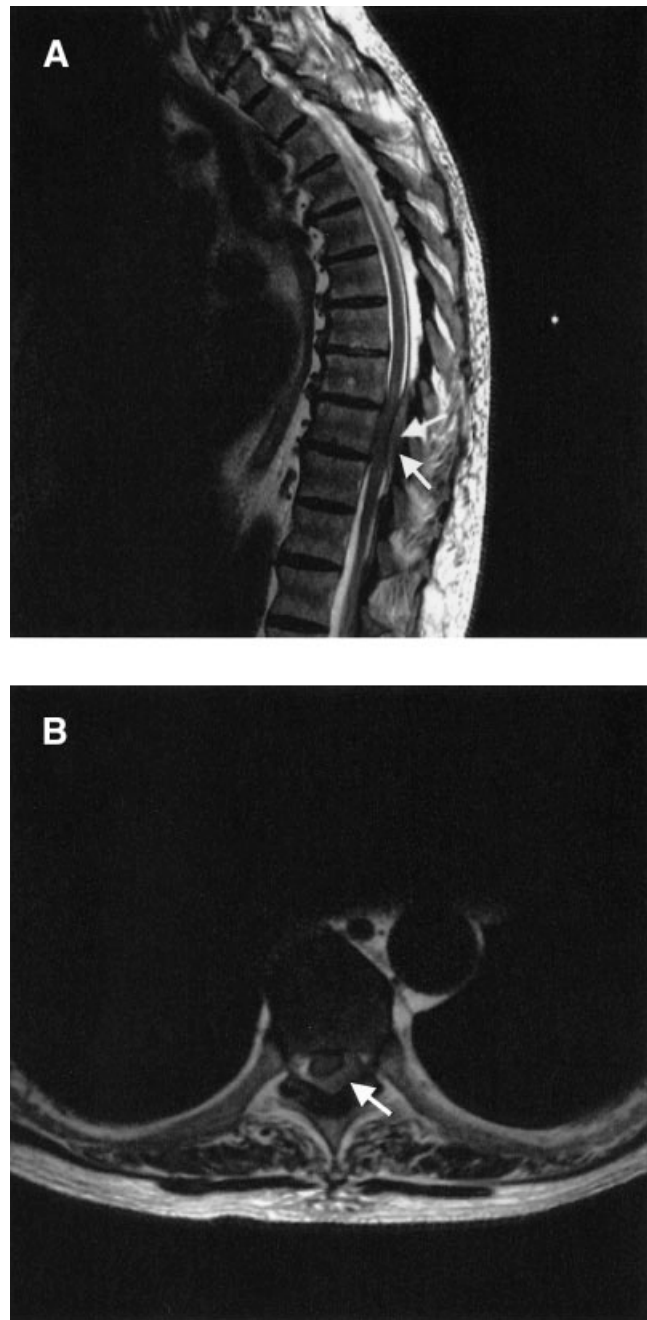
(A) Magnetic resonance imaging of the spine shows an enhancing epidural mass (arrows) from T8 to T10. (B) Axial imaging reveals the mass is predominantly on the left and is causing spinal cord compression at T9.
